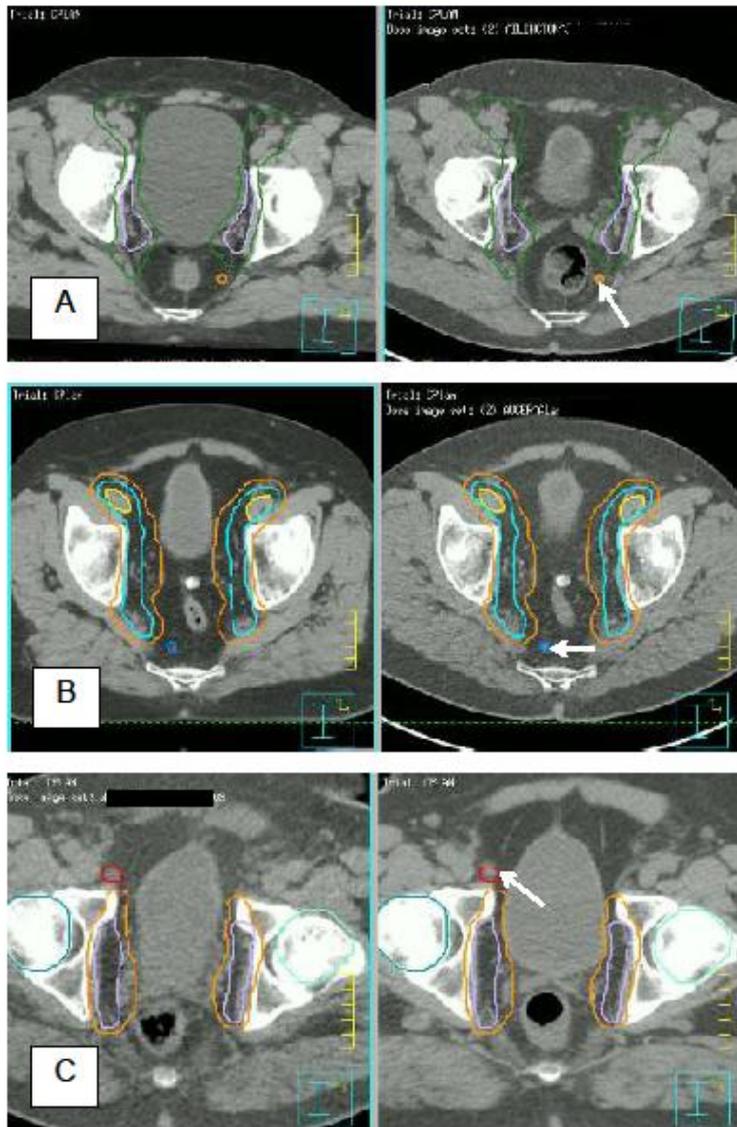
Planning CT scans (left) and corresponding Choline PET scans (right) showing examples of nodes covered by radiation contours.
